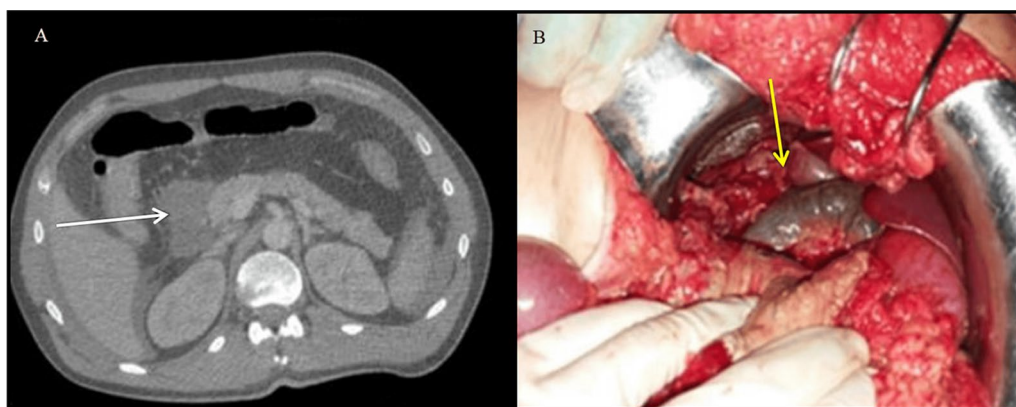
Extensive gastric and duodenal necrosis following caustic product ingestion in a patient who underwent surgery. A contrast CT Axial slice of the abdomen, showing a non-enhancing duodenal wall with fat stranding CT score III (white arrow). B Peroperative picture matching with an extensive gastroduodenal necrosis (Yellow arrow)
